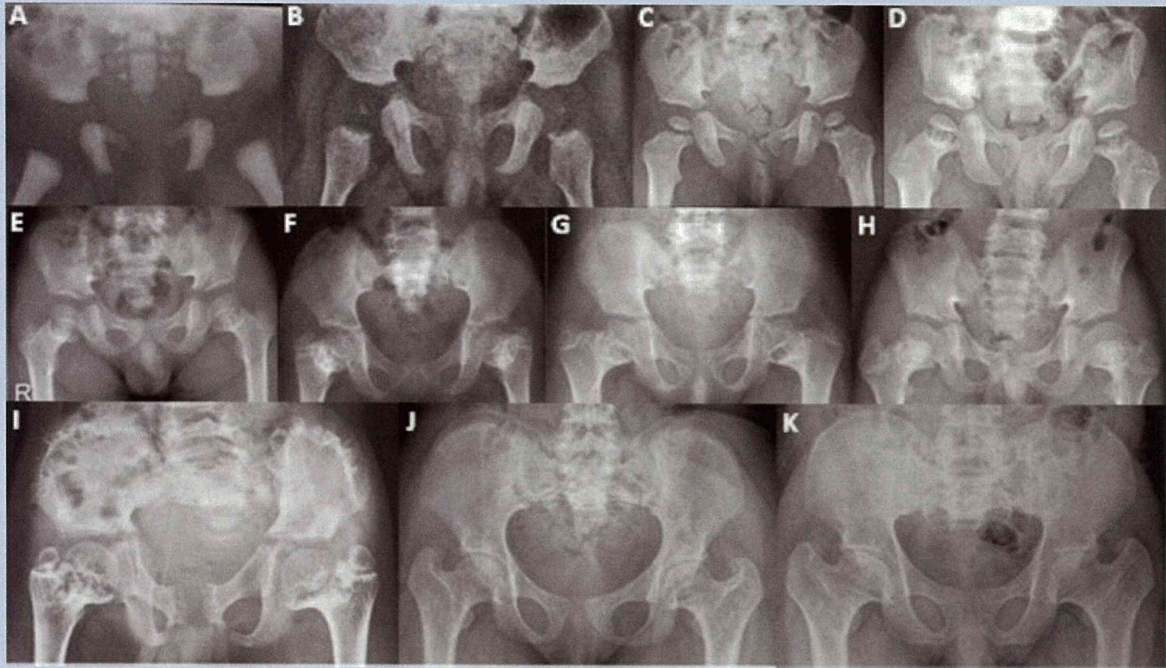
Radiographs of pelvis. A: Patient 1 at 2 days. The ilia are somewhat hypoplastic but lacy ilia are not evident. B: Patient 1 at age 6 months. The iliac crests are somewhat irregular. C: Patient 2 at age 1 ^{4/12} years. The iliac crests and proximal femoral metaphyses are irregular. D: Patient 3 at age 4 years, (E) Patient 4 at age 5 years. Lacy ilia and metaphyseal irregularities of the proximal femora are apparent. F: Patient 6 at age 8 years, (G) Patient 7 at age 10 years, (H) Patient 4 at age 10 years, (I) Patient 5 at age 12 years. Proximal femoral metaphyseal irregularities with coxa vara are conspicuous in all patients. Lacy ilia are varied among the patients. J: Patient 6 at age 15 years, (K) Patient 7 at age 23 years. Lacy ilia and metaphyseal irregularities already diminish, but coxa vara is persistent.
